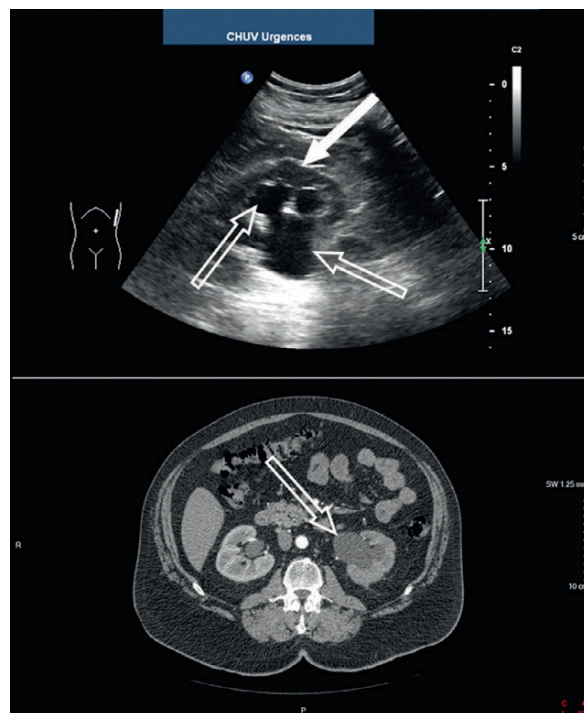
Echographic (top) and contrast-enhanced computed tomography scan (bottom) of a left-kidney hydronephrosis in a patient with spinal cord injury. White solid arrow, left-kidney parenchyma; white open arrow, dilated renal pelvis.
